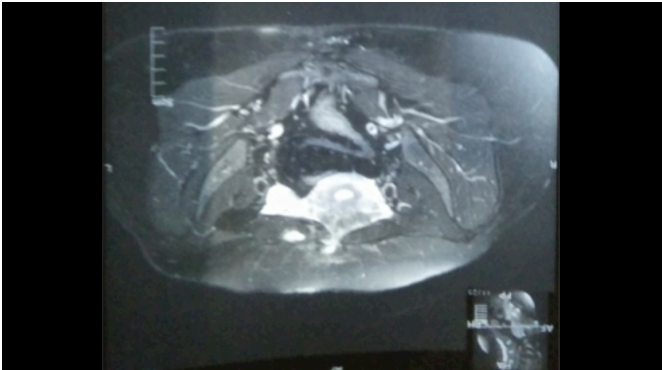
MRI showing fistulous tract from uterine cavity to anterior abdominal wall.
